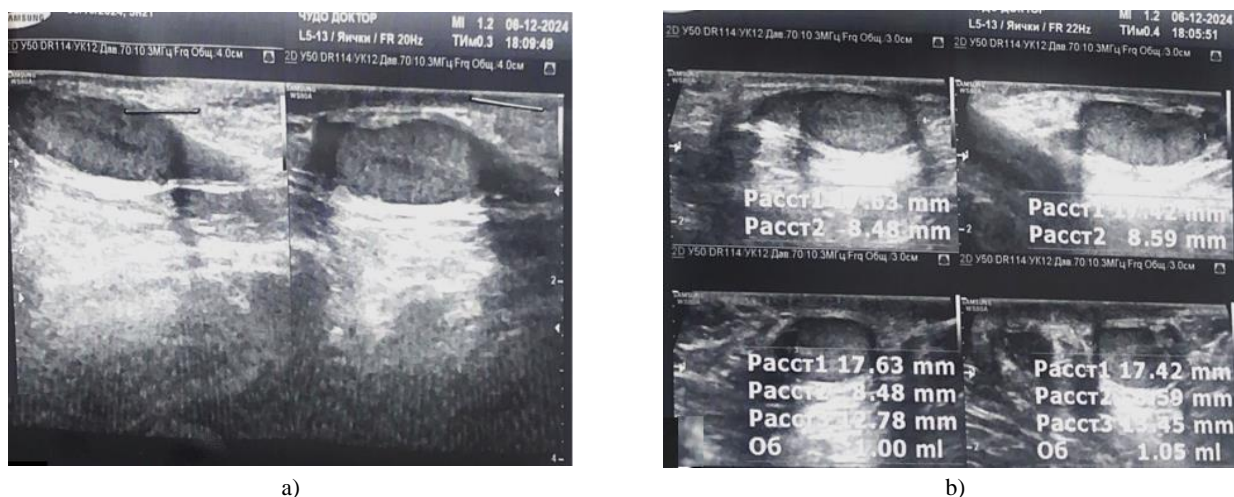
Sonographic evaluation demonstrating cryptorchidism associated with testicular hypoplasia (a) and (b). The affected testis exhibits a hypoechoic texture, reduced dimensions, and diminished vascularity compared to normative testicular parenchyma.
